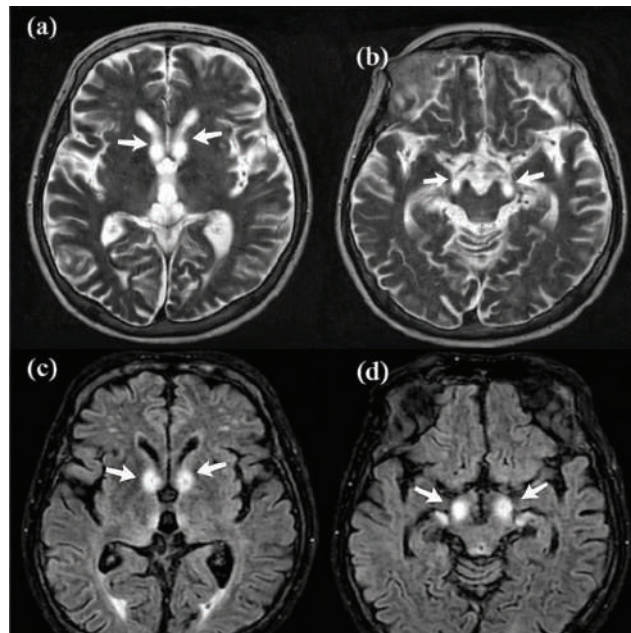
Typical lesions on MRI of Wernicke encephalopathy[6]
